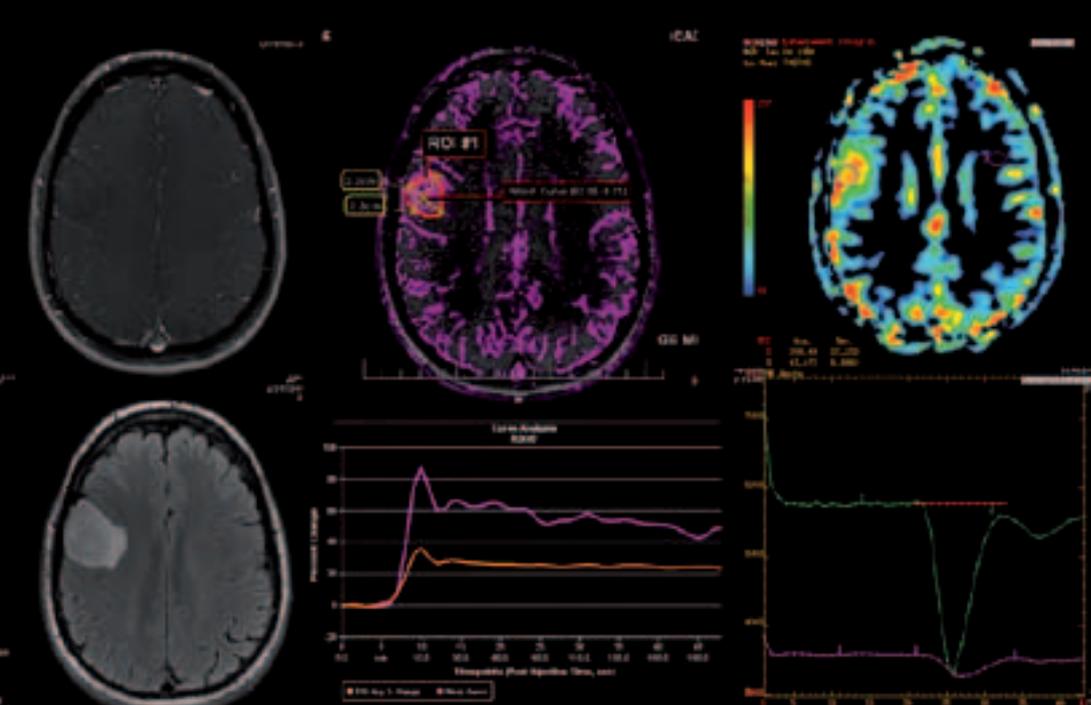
Glioma demonstrates increased permeability on DCE MRI and increased relative cerebral blood volume on DSC MRI, despite lack of contrast enhancement. This underlines the importance of biological imaging in neuro-oncology. (Provided by Prof. M. Law)
